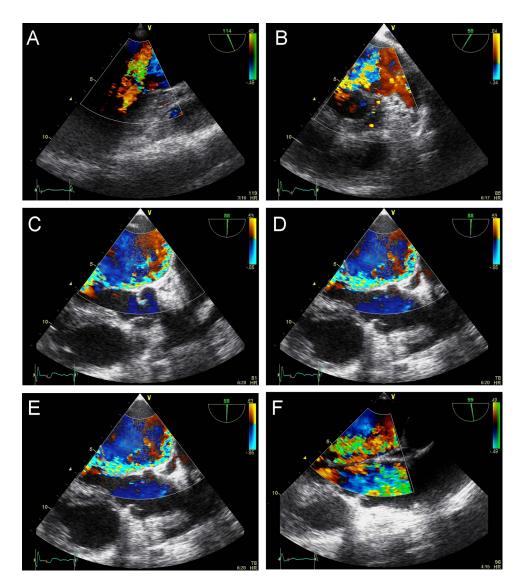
Transoesophageal echocardiography: colour Doppler imaging demonstrates the jet of mitral regurgitation during an episode of haemolysis.
